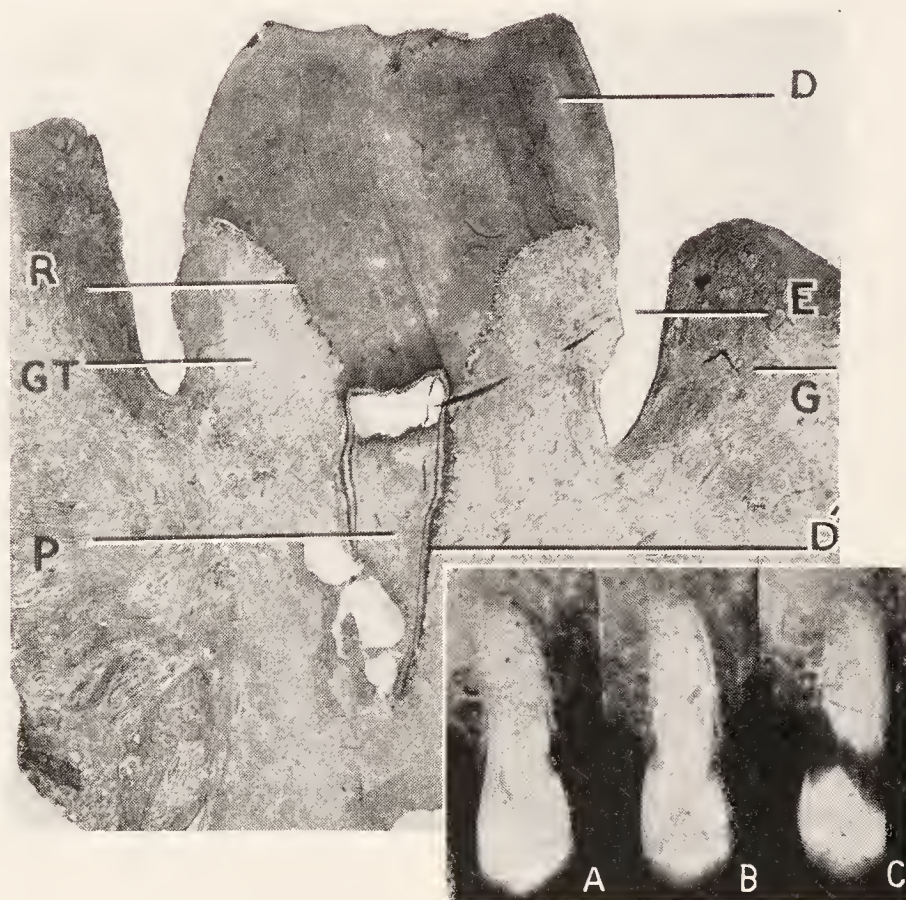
Extensive resorption of roots and crown of the upper right second bicuspid in a case of rapid resorption of the permanent set of teeth of a woman, aged thirty-eight years. The three radiographs in the right lower corner show the rapid progress of destruction of this tooth. *A*, January 19, 1929: shallow indentation on the distal side of the crown. *B*, March 6, 1929: indentation on both the mesial and distal side of the root. *C*, May 27, 1929: in less than three months the defects visible in *B* have become confluent in the middle of the tooth, so that crown and root appear to be almost entirely separated. Mesio-distal section through the crown portion of the bicuspid: *D*, dentin; *E*, enamel; *G*, gingival tissue; *R*, resorption undermining the enamel; *GT*, granulation tissue; *P*, pulp; *D'*, dentinoid and dentin surrounding the pulp. (Mueller, Jour. Am. Dent. Assn.)
